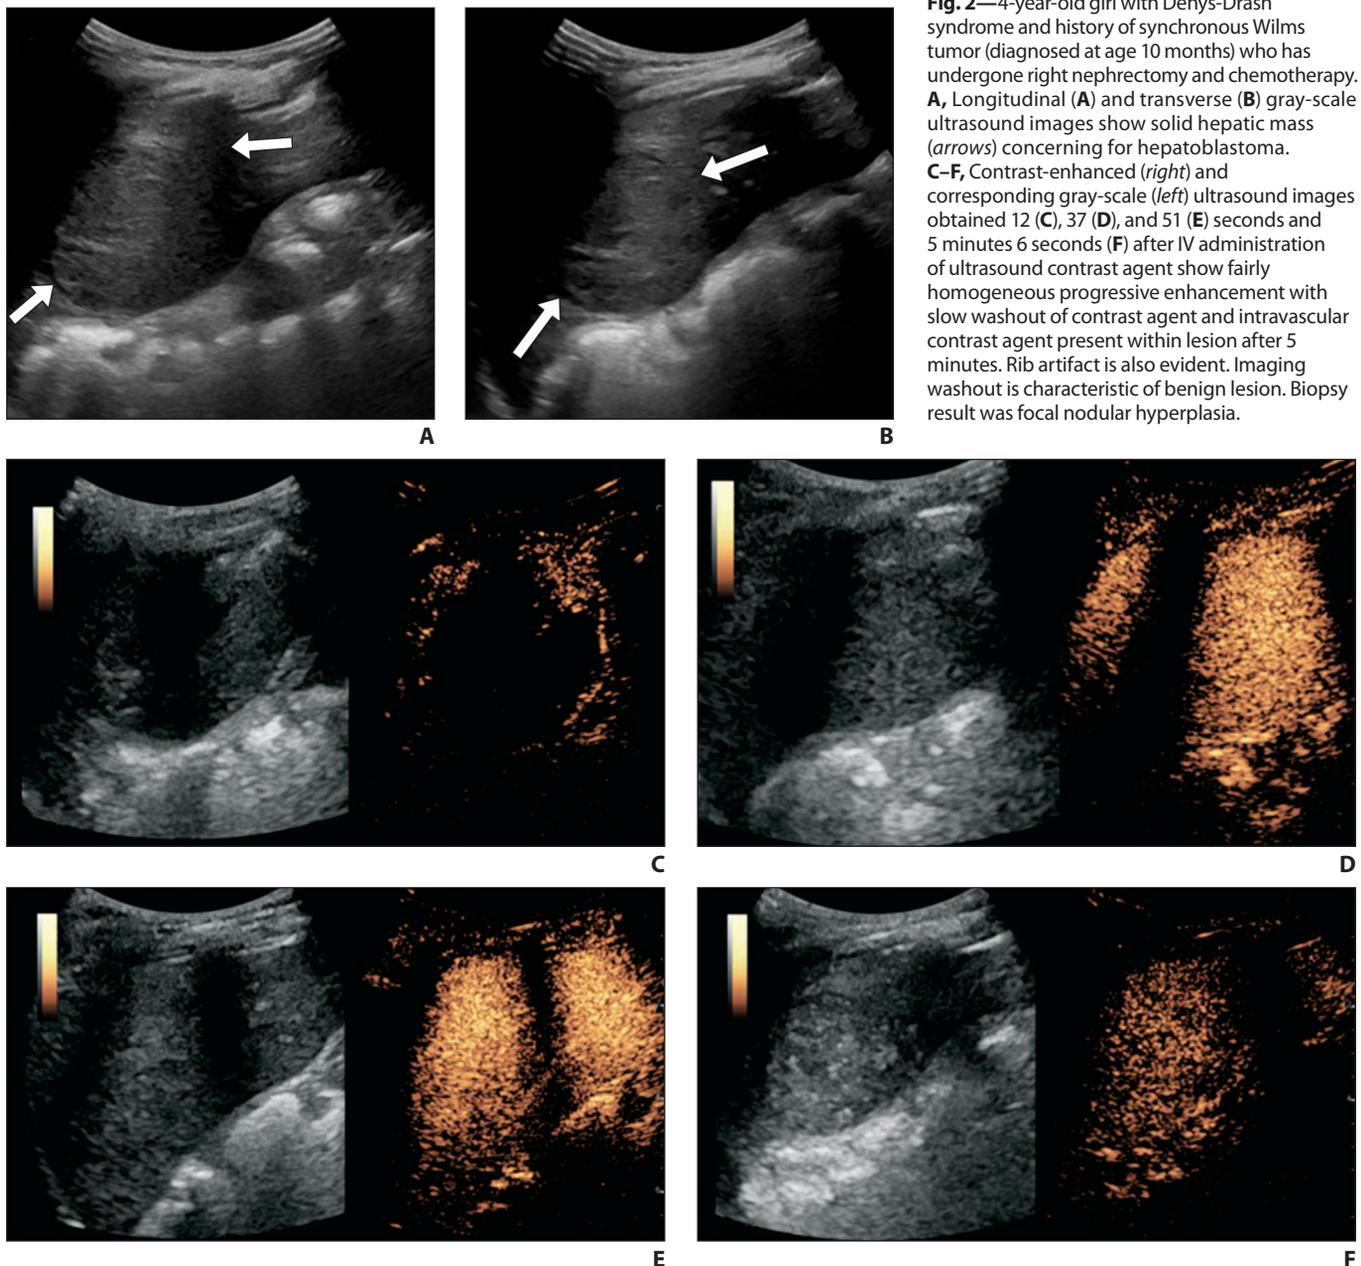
4-year-old girl with Denys-Drash syndrome and history of synchronous Wilms tumor (diagnosed at age 10 months) who has undergone right nephrectomy and chemotherapy. A, Longitudinal (A) and transverse (B) gray-scale ultrasound images show solid hepatic mass (arrows) concerning for hepatoblastoma. C–F, Contrast-enhanced (*right*) and corresponding gray-scale (*left*) ultrasound images obtained 12 (C), 37 (D), and 51 (E) seconds and 5 minutes 6 seconds (F) after IV administration of ultrasound contrast agent show fairly homogeneous progressive enhancement with slow washout of contrast agent and intravascular contrast agent present within lesion after 5 minutes. Rib artifact is also evident. Imaging washout is characteristic of benign lesion. Biopsy result was focal nodular hyperplasia.
